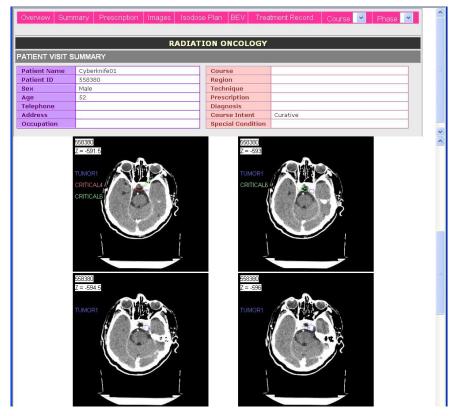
Display Window showing CT diagnostic images overlaid with critical structures obtained from the Cyberknife treatment system. The contours enclosing the tumor (TUMOR1, blue), the optic chiasm (CRITICAL4, red), and the left nerve (CRITICAL6, green) all happen to be displayed on this particular upper lefthand CT image slice.
